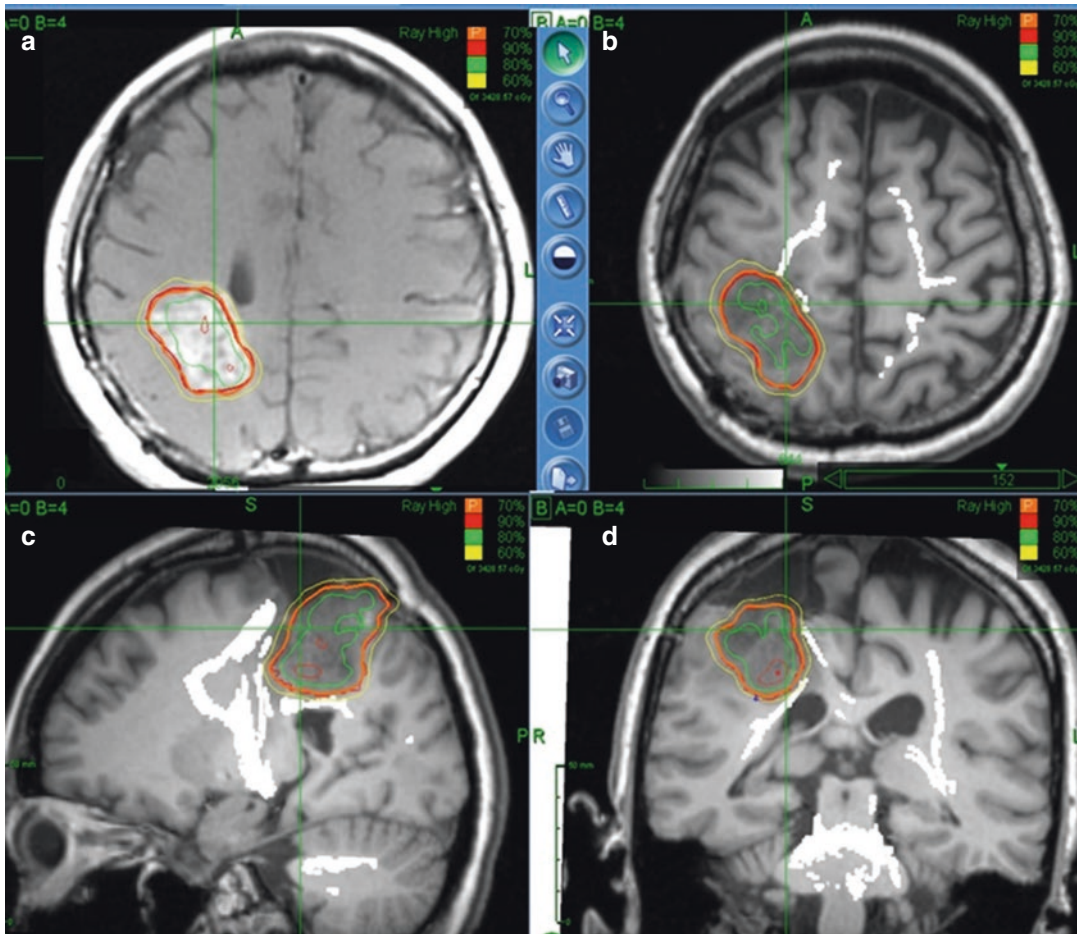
Contrast-enhanced MRI showed the tumor and treatment planning (a), and the corticospinal tracts (the white bundles) were visualized in axial (b), sagittal (c) and coronal (d) MR imaging
